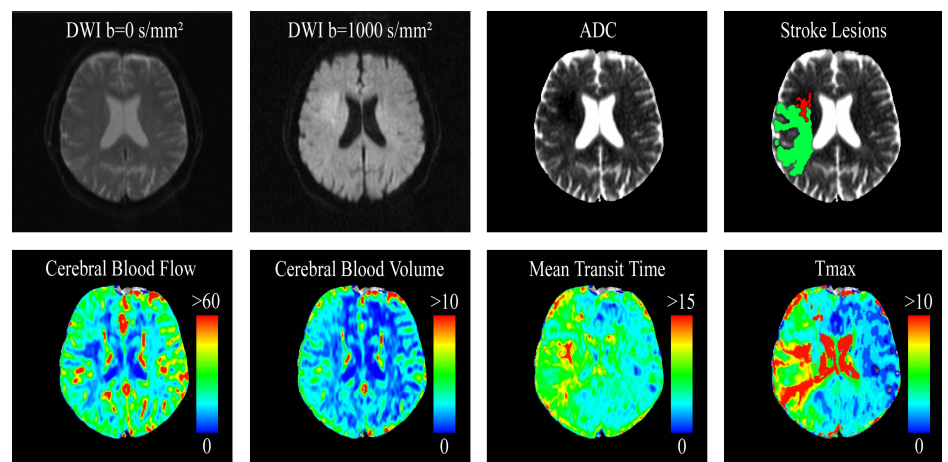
Selected slice from a DWI dataset and corresponding ADC parameter dataset used for definition of the diffusion lesion (red lesion) as well as perfusion parameter maps CBF (in ml/100g/s), CBV (in ml/100g), MTT (in s), and Tmax (in s). Tmax >6s is also used for tissue-at-risk definition (green)
